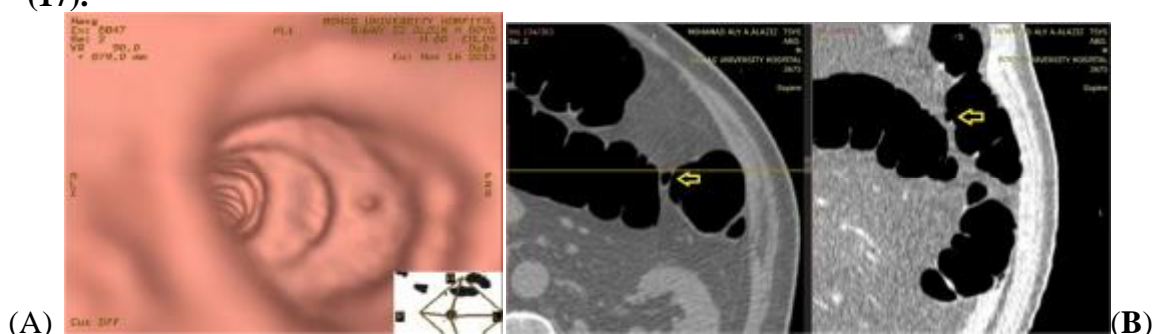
Diverticula in the descending colon. (a) 3D virtual endoscopic CT image shows a complete dark ring at the diverticula. (b) Supine 2D axial CT image shows multiple gas-filled outpouchings of the colon wall.
